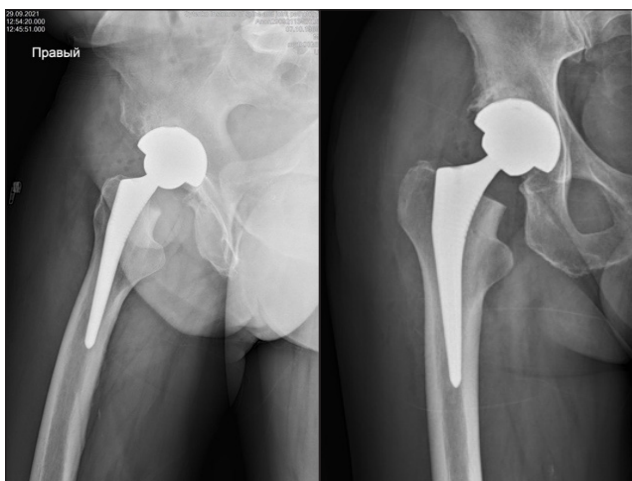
X-ray images of the joint on the 7th day after hip replacement surgery and bone defect reconstruction
